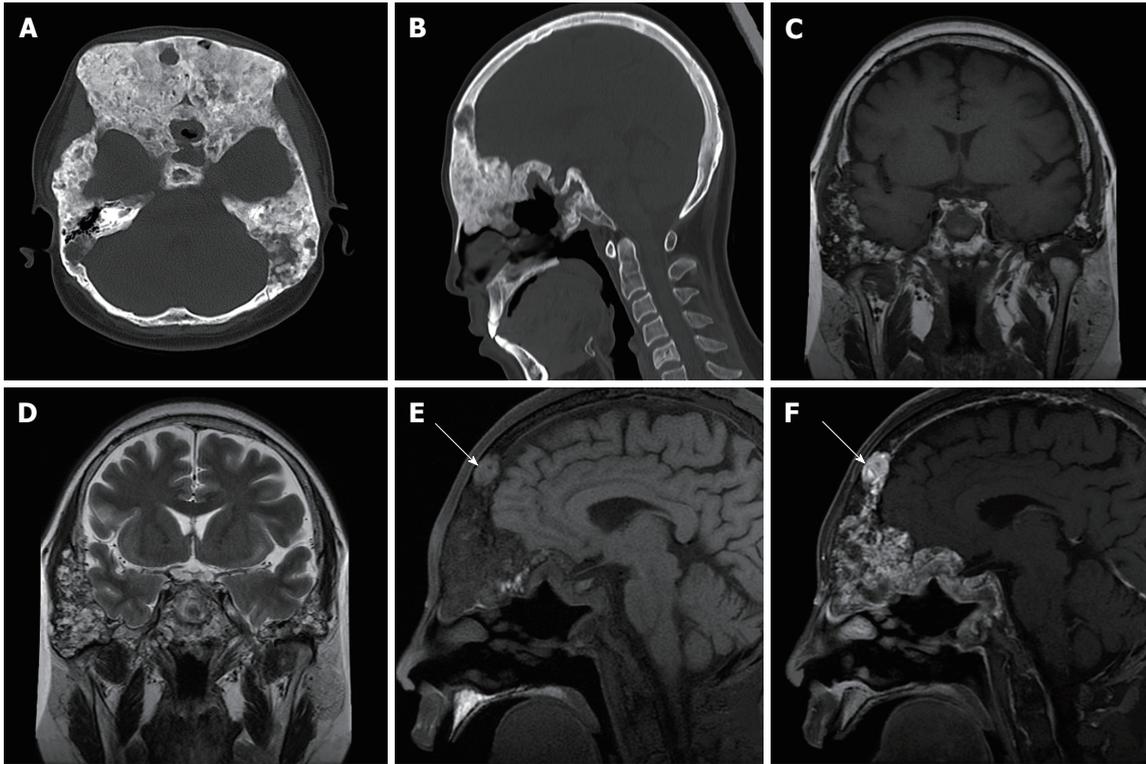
Computed tomography and magnetic resonance imaging images of Patient 1. A and B: Axial and sagittal skull computed tomography images showing that the skull and maxillofacial bones were remarkably enlarged with both sclerotic and lytic lesions; C-F: Coronal T1-weighted image (C) and T2-weighted image (D) showing bone lesions with heterogeneous signal intensity in the temporal and sphenoid bones; hyperintensity in the frontal bone was found on the fat saturated T1-weighted image (E, arrow), indicating mucus; the bone lesions were markedly enhanced after enhancement (F).
